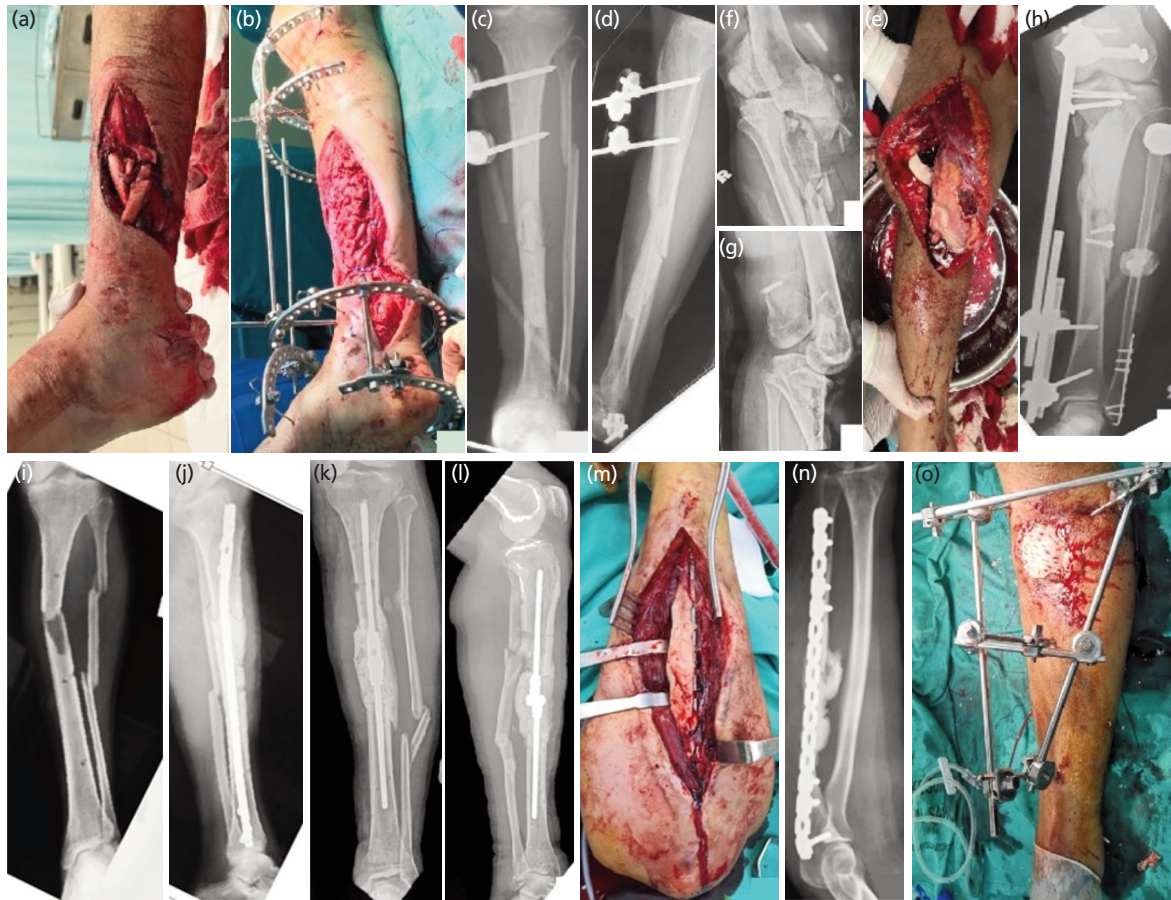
Different fixation choices for Stage 1. (a) Belongs to Case 1 and shows a Gustilo-Anderson Grade IIIB open distal tibial fracture with a soft-tissue defect and bone comminution before debridement. (b) Also belongs to Case 1 and shows a cross-ankle Ilizarov external fixator with a medial hemisoleus flap covering the cement spacer over the bone defect. (c, d) Belong to Case 2, a tibial fracture-related infection that required bone resection, and are anteroposterior (AP) and lateral radiographs of the tibia showing a cross-ankle external fixator and an intercalary cement spacer. (e) Belongs to Case 4 and shows a severe open fracture-dislocation of the knee. (f, g) Also belong to Case 4 and are radiographs of the knee demonstrating the fracture-dislocation associated with severe tibial metaphyseal bone loss. (h) Belongs to Case 4 and shows the post-operative radiograph following fixation of the distal femur and proximal tibial articular surfaces with screws, reconstruction of the metaphyseal bone defect with bone cement, and application of a cross-knee external fixator. (i) Belongs to Case 6, an open tibial fracture with a critical-sized bone defect, and shows a radiograph of the tibia demonstrating the bone defect. (j) Shows the Stage 1 fixation using an intramedullary nail and bone cement to fill the defect. (k, l) Belong to Case 7, a tibial fracture-related infection associated with an intercalary bone defect, and show radiographs obtained after Stage 1 surgery, demonstrating an intercalary cement spacer with a cement-coated threaded rod and an Ilizarov hinge. (m) Belongs to Case 8, an ulnar fracture-related infection with a bone defect, and shows plate fixation with a cement spacer. (n) Also belongs to Case 8 and shows the post-operative Stage 1 radiograph of the oversized cement spacer. (o) Belongs to Case 9, a Gustilo-Anderson Grade IIIB open proximal tibial fracture with associated bone and soft-tissue defects. A medial gastrocnemius flap was used to cover the bone cement spacer, which was stabilised with a tibial external fixator.
